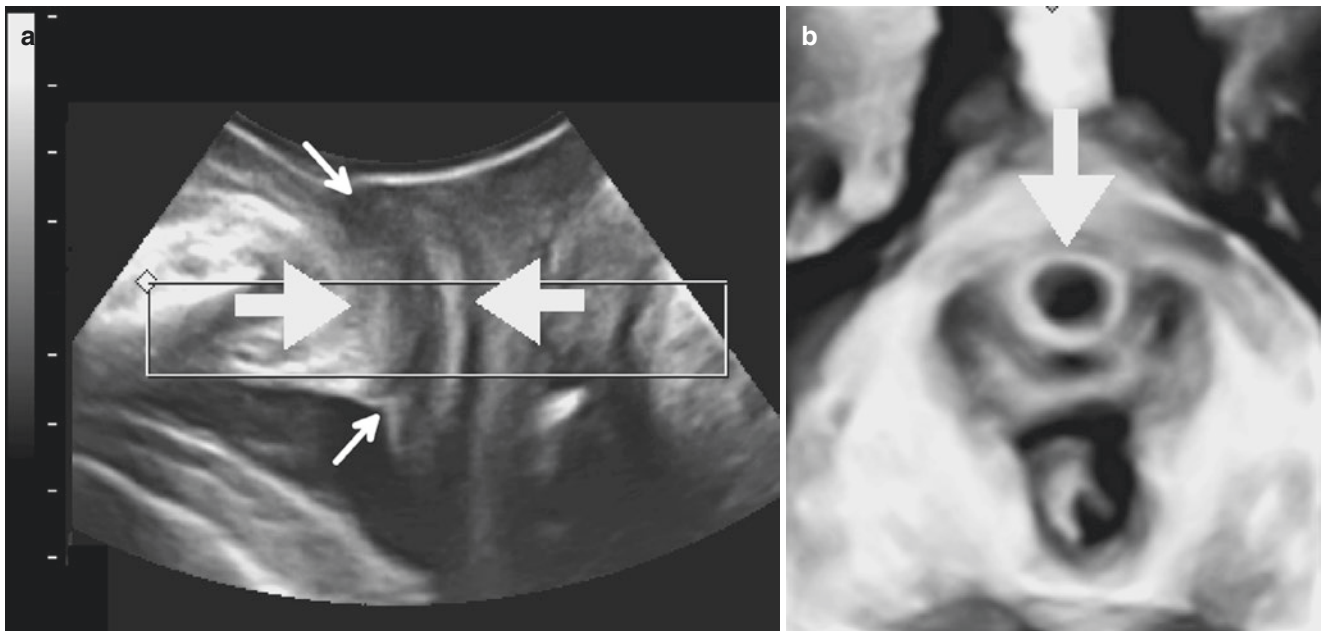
The urethra as seen on translabial 4D ultrasound. The midsagittal plane is on the left (a). Small arrows show the external meatus at the top, and the internal urethral meatus at the bottom. Large arrows
